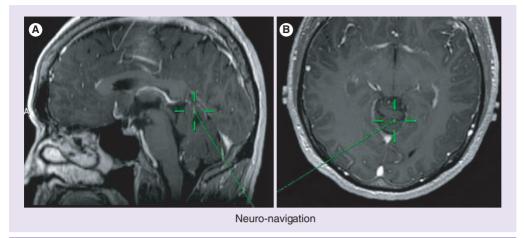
Post-gadolinium enhanced T1 MRI showing a 49 year-old man with a cerebellar vermis high-grade glioma. (A) Sagittal and (B) axial. Shown are the neuro-navigation (green) trajectories intra-operatively, demonstrating the supracerebellar–infratentorial approach that was used for operative resection of this tumor.
